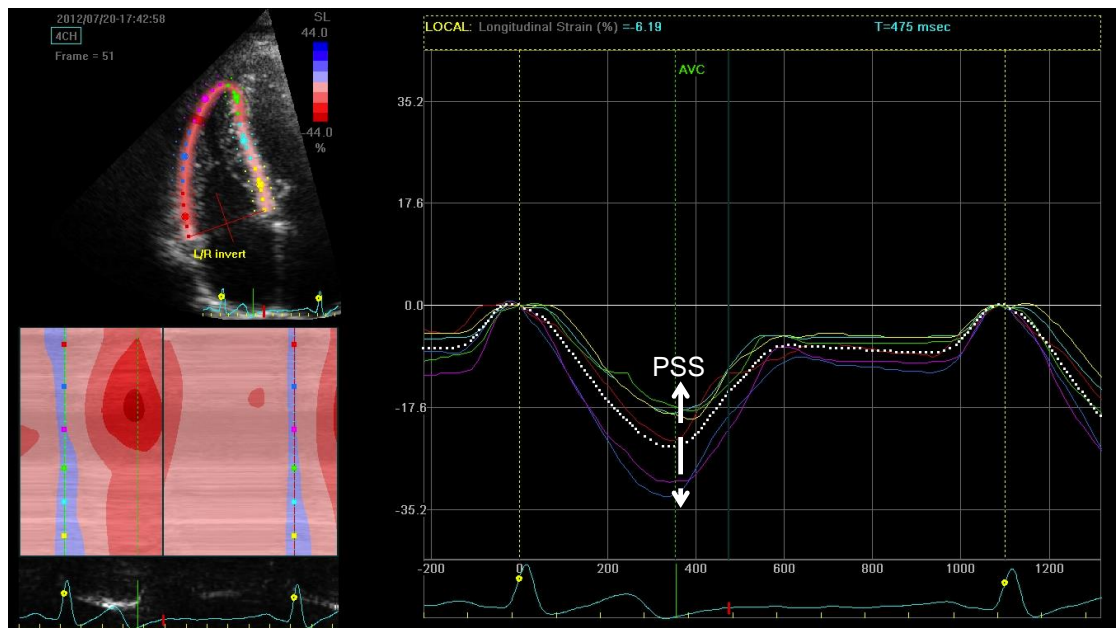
RV speckle tracking echocardiography displaying tracking of both the septal and RV freewall as a six segment ‘global’ longitudinal strain curve. The horizontal dotted white line represents the global measurement derived from the six coloured traces. The vertical dashed lines shows the approximate measurements of peak systolic strain (PSS) (%).
